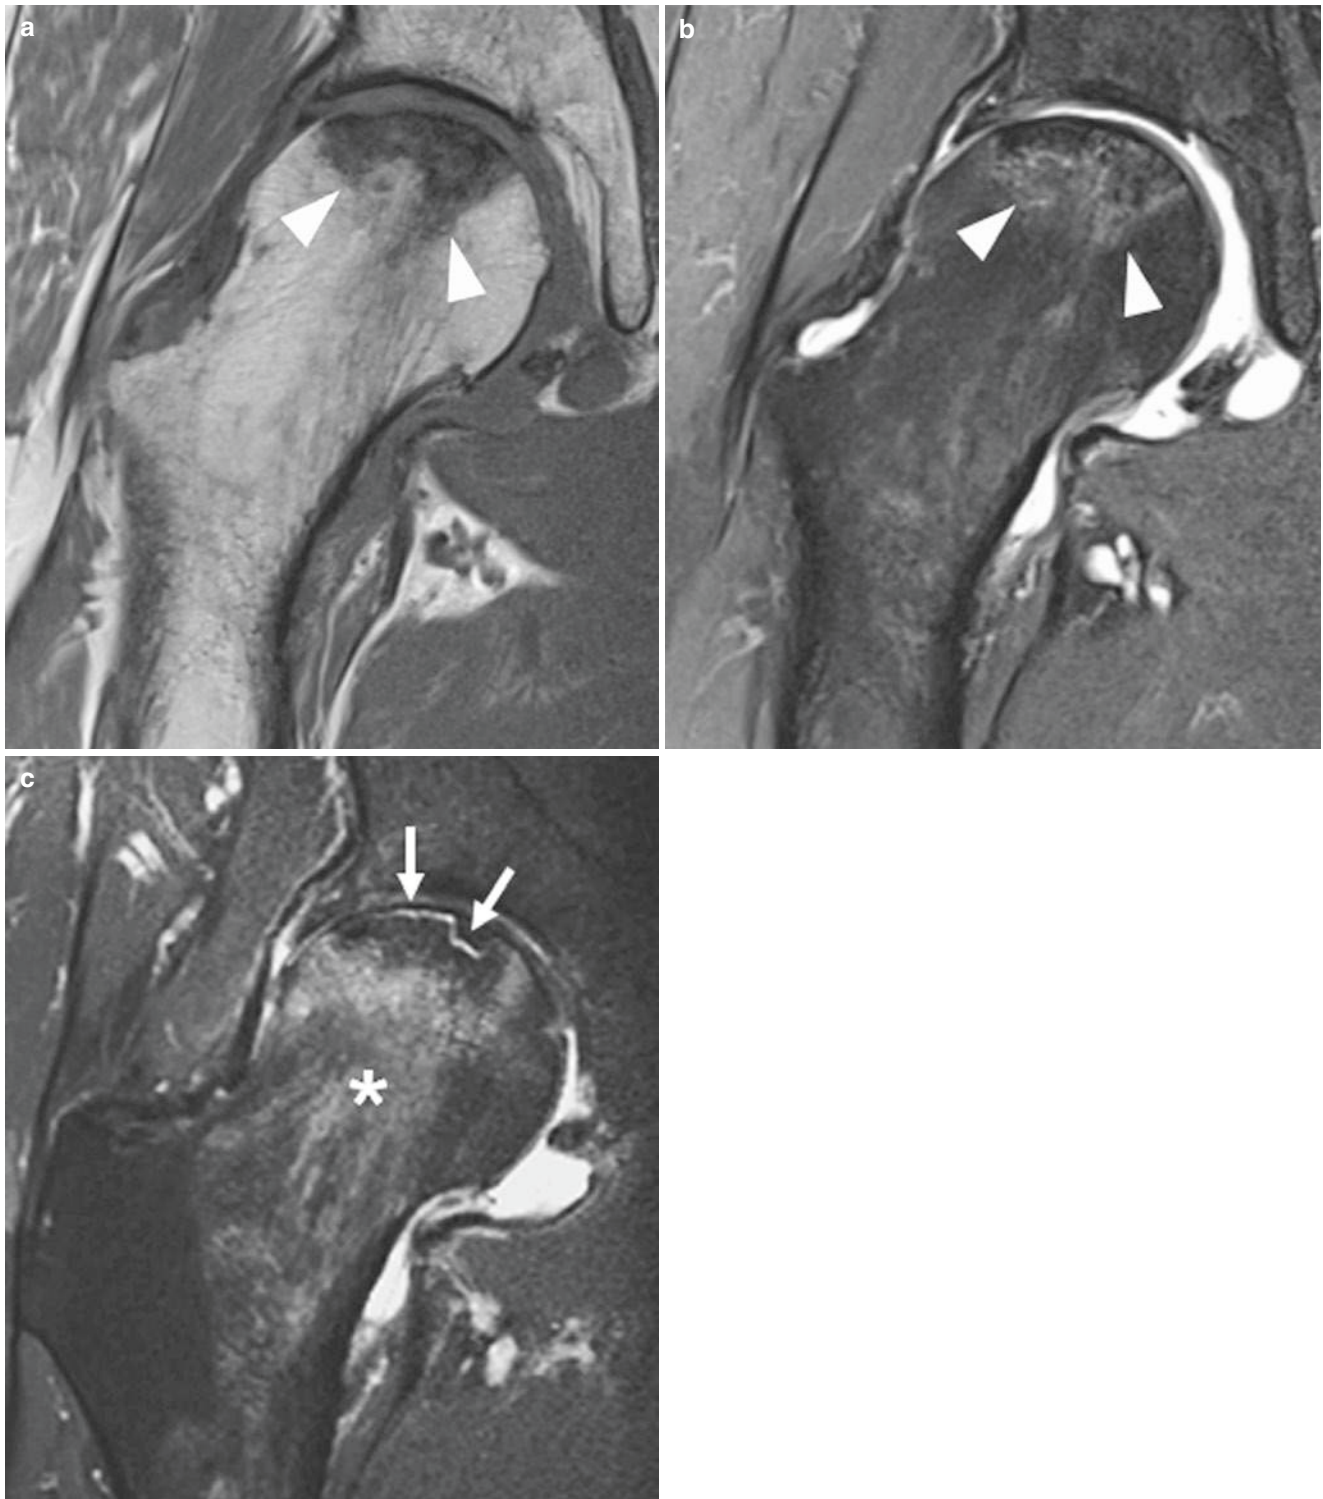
(a–c) AVN of the femoral head: progression from ARCO stage 2 to stage 3. (a) Coronal T1-weighted TSE image and (b) corresponding intermediate weighted TSE image with fat suppression show hypointense subchondral segment of osteonecrosis demarcated by a reactive interface (*arrowheads*). Note absence of femoral head collapse
